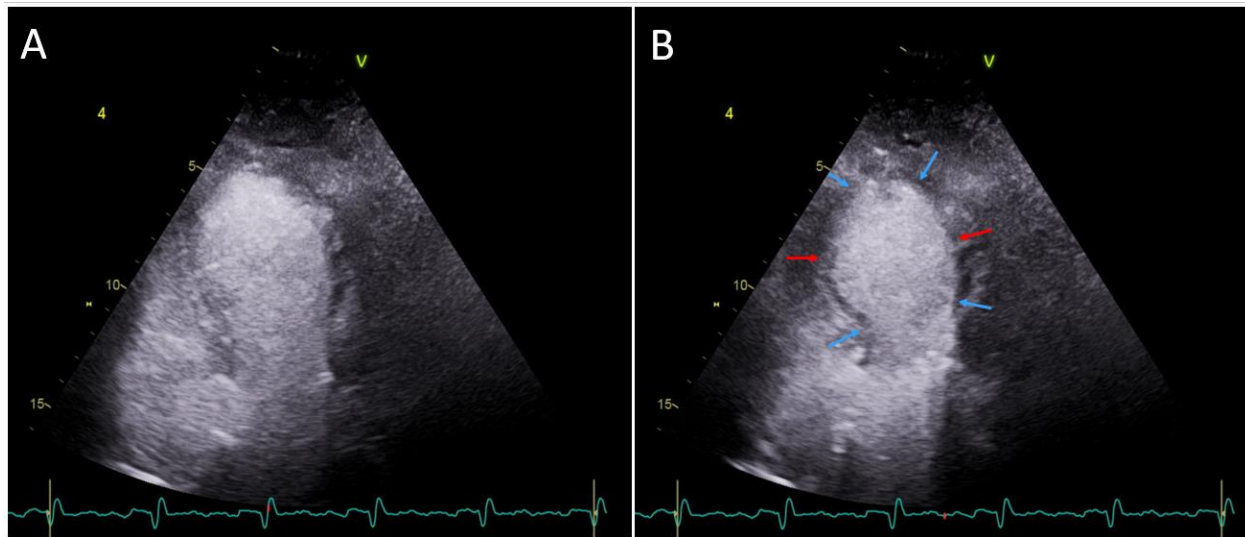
Four chamber view of the transthoracic echocardiogram demonstrating left ventricular diastole (A) and systole (B). The mid ventricular wall segments are hypokinetic (red arrows). The basal and apical segments are hyperkinetic (blue arrows).
